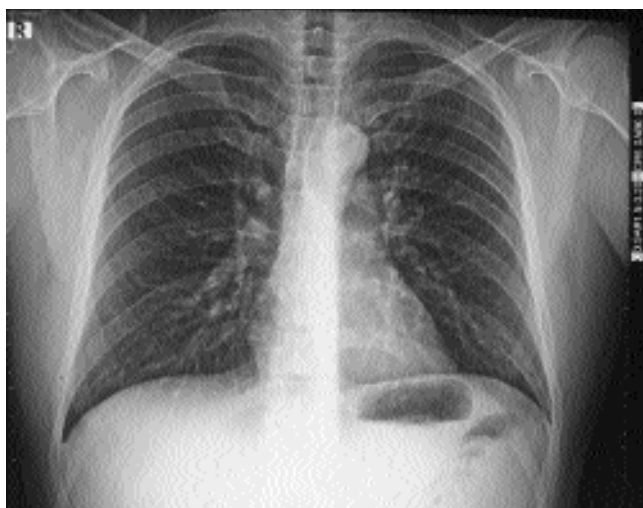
No recurrence at plain film radiograph taken in year 2013.
